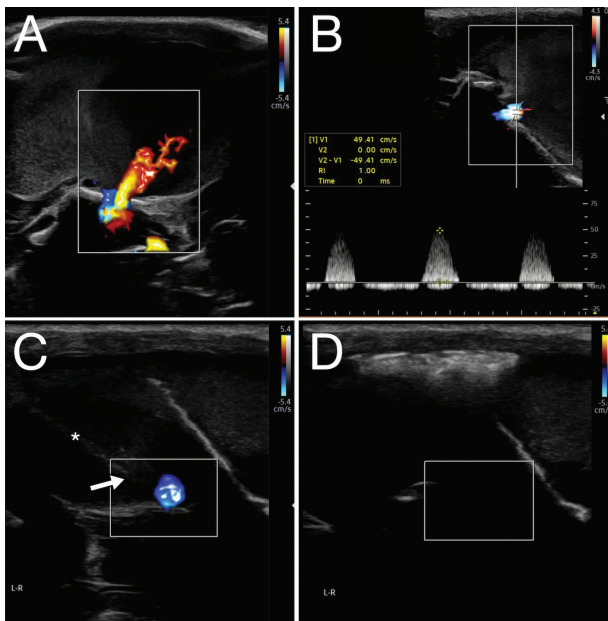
A and B—Color Doppler ultrasound of the left temporo-orbital mass. There is swirling hyperechoic fluid within the mass. A vessel with a high-velocity, pulsatile jet (49.4 cm/s) is identified feeding the mass. C—A needle (asterisk) is inserted into the mass and advanced toward the feeder vessel, with the tip of the needle (arrow) as close as possible to the identified jet. D—After injection, the jet is interrupted. Gas and cyanoacrylate cause acoustic shadowing.
